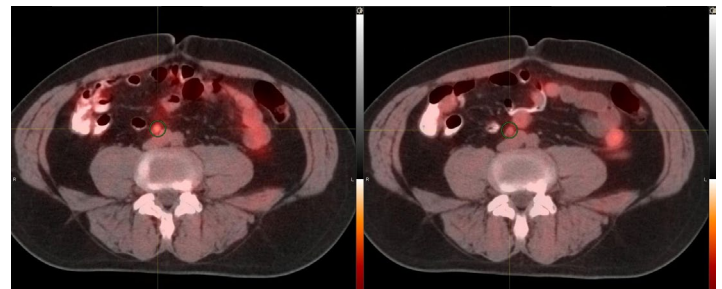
59 y/o, Gleason 9 (4+5), treated with prostatectomy and subsequent salvage radiation therapy to the bed for rising PSA 1 year later. Rising PSA 1 1/2 years later, and at the time of AC PET/CT imaging, was 0.7 ng/mL. The left image shows a sub-centimeter focally metabolic lymph node in the left external iliac region on early imaging (SUVmax 3.22, L/B 2.73). The right image shows the same finding in the lymph node on the later imaging but with this appearing less conspicuous (SUVmax 2.36, L/B 1.92).
